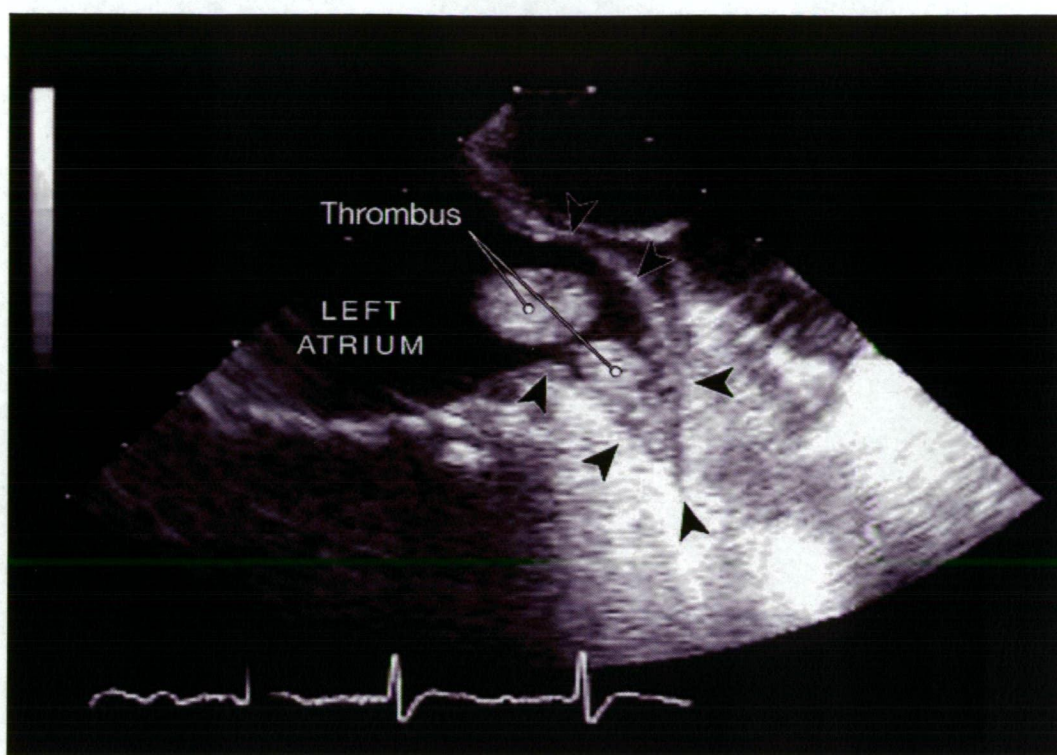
Transesophageal echocardiographic image of a thrombus in the left atrial appendage in a patient with AF.
